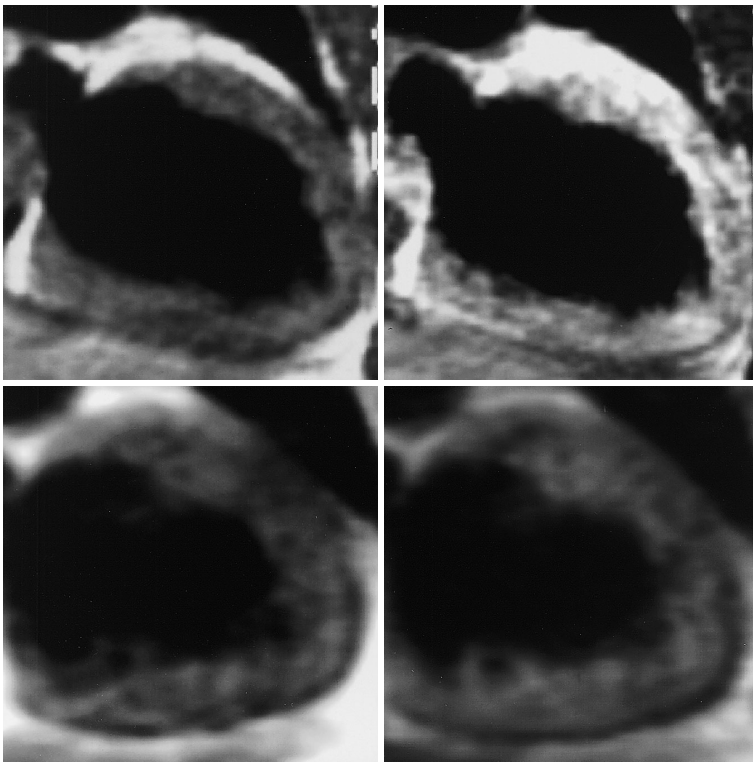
Magnetic resonance images
